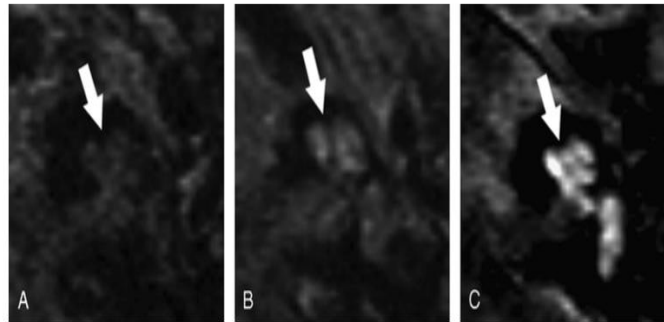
A-C, Grading of cochlear enhancement. Axial gadolinium-enhanced T1-weighted MRI showing different grades of cochlear enhancement after contrast admission (arrows). A, Grade 0: no enhancement of the cochlea (Patient 14). B, Grade 1: moderate enhancement (Patient 9). C, Grade 2: severe cochlear enhancement (Patient 13).
